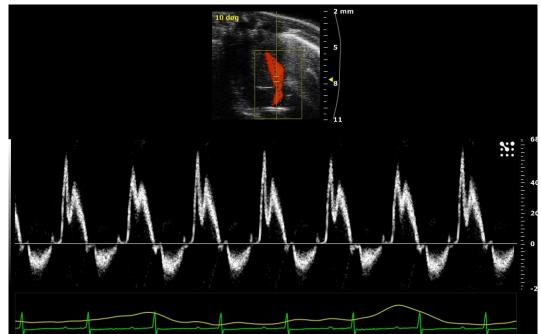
Color Doppler Mode image displaying flow through the Mitral Valve.
